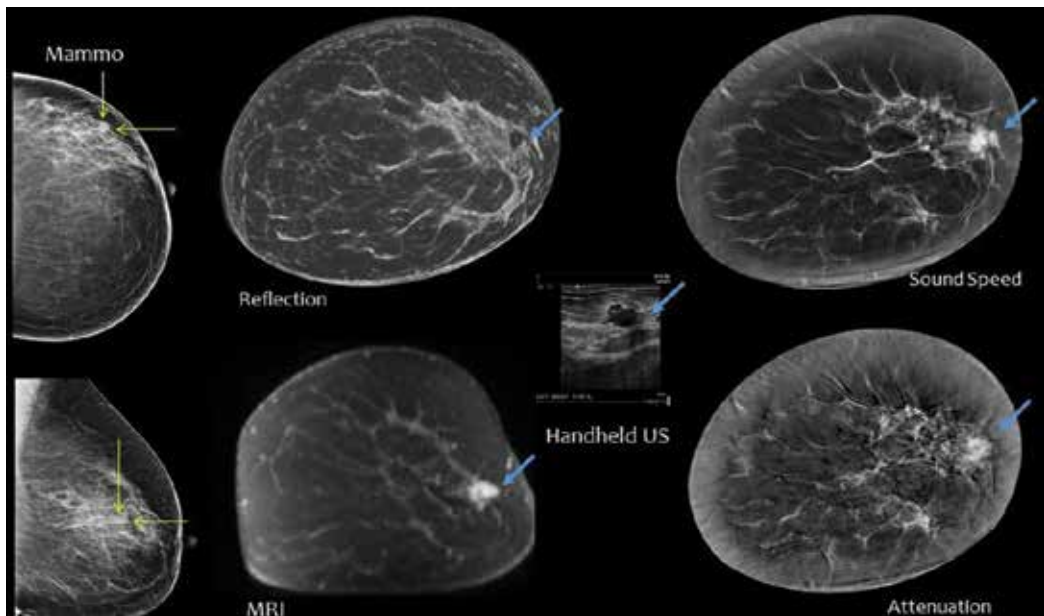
A 9 mm IDC at 3 o'clock. CC and MLO mammographic views of the affected breast are shown on the left with the lesion identified by arrows. The coronal UST views are shown in the form of reflection, sound speed and attenuation images. The corresponding ultrasound and MR images are also shown.
